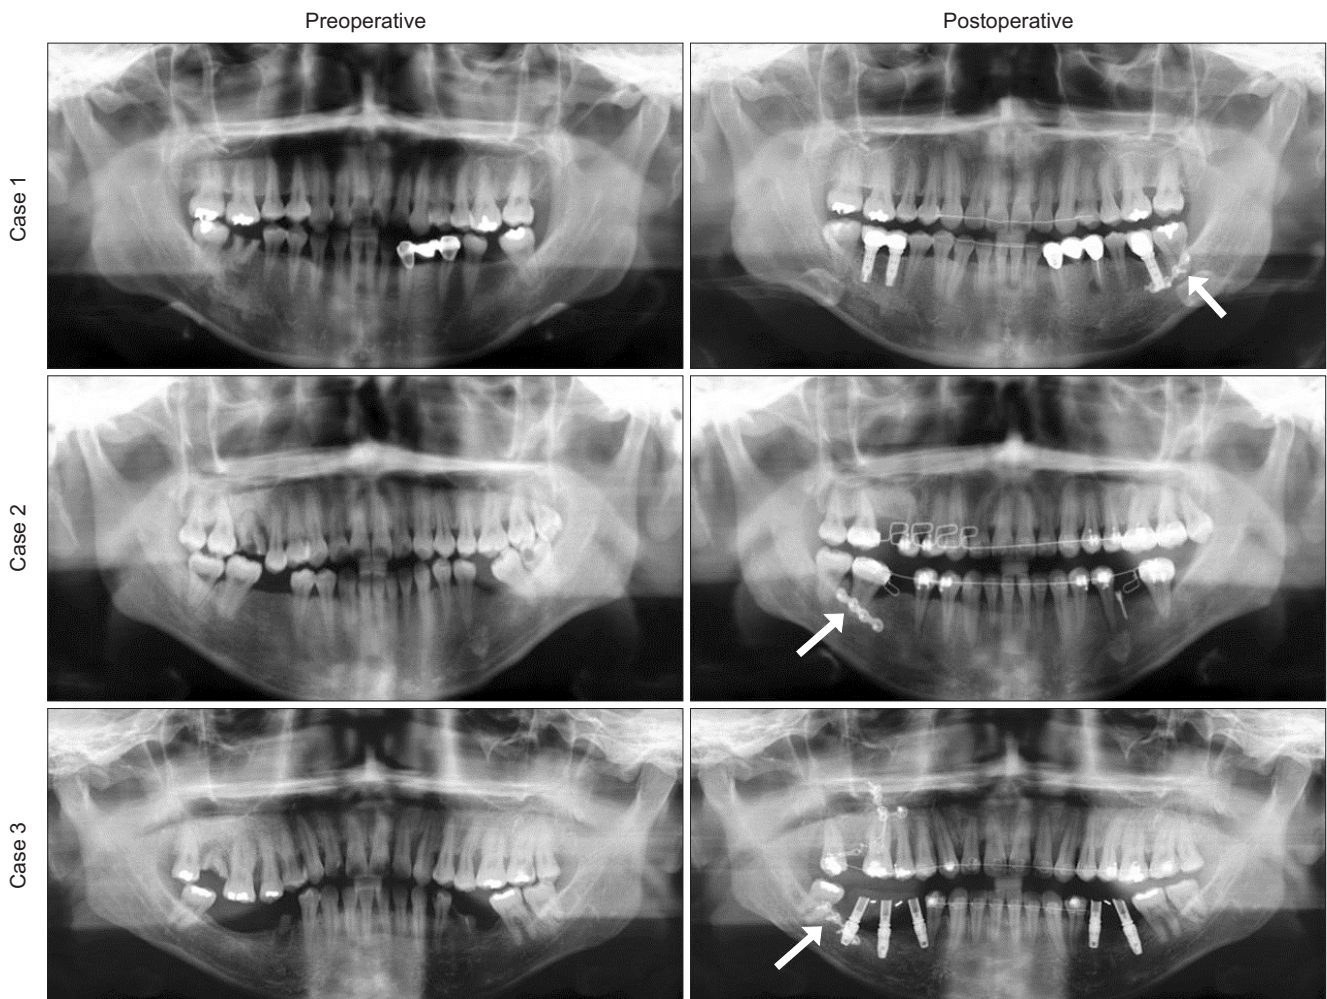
Preoperative and 2-year postoperative panoramic radiography of present cases. The osteotomy sites and remaining miniplates are indicated by arrows. On postoperative panoramic radiography, all cases show symmetric mandibular condylar size and ramus height, and no evidence of condylar resorption after unilateral sagittal split ramus osteotomy.
